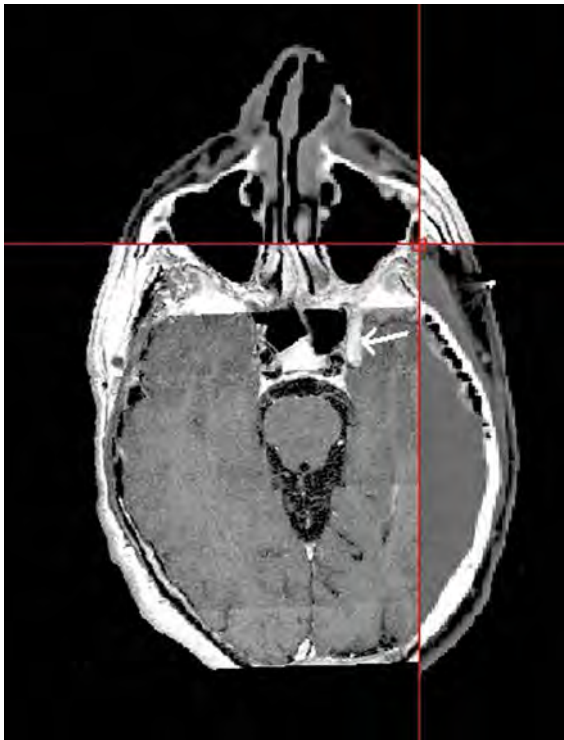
Example of CT/MRI fusion image. A 48-year-old male presented with recurrence of a squamous cell carcinoma of the facial skin with perineural spread along the infraorbital nerve into the fossa pterygopalatina, and extension to the lateral left cavernous sinus (*arrow*)
